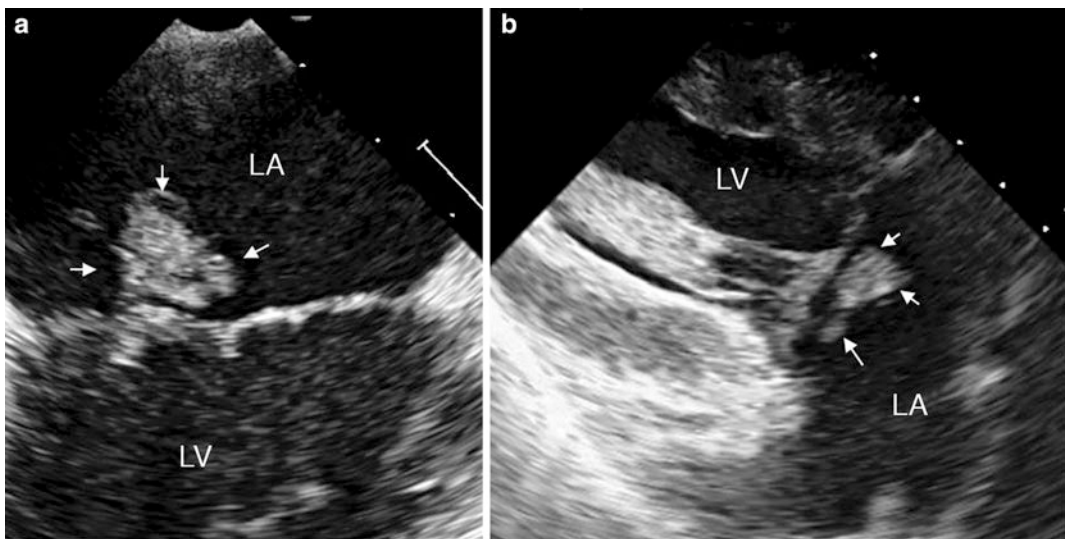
Large-scale endocarditic vegetation (arrows). Image obtained (a) with a transesophageal and (b) transgastric approach. LA left atrium, LV left ventricle
